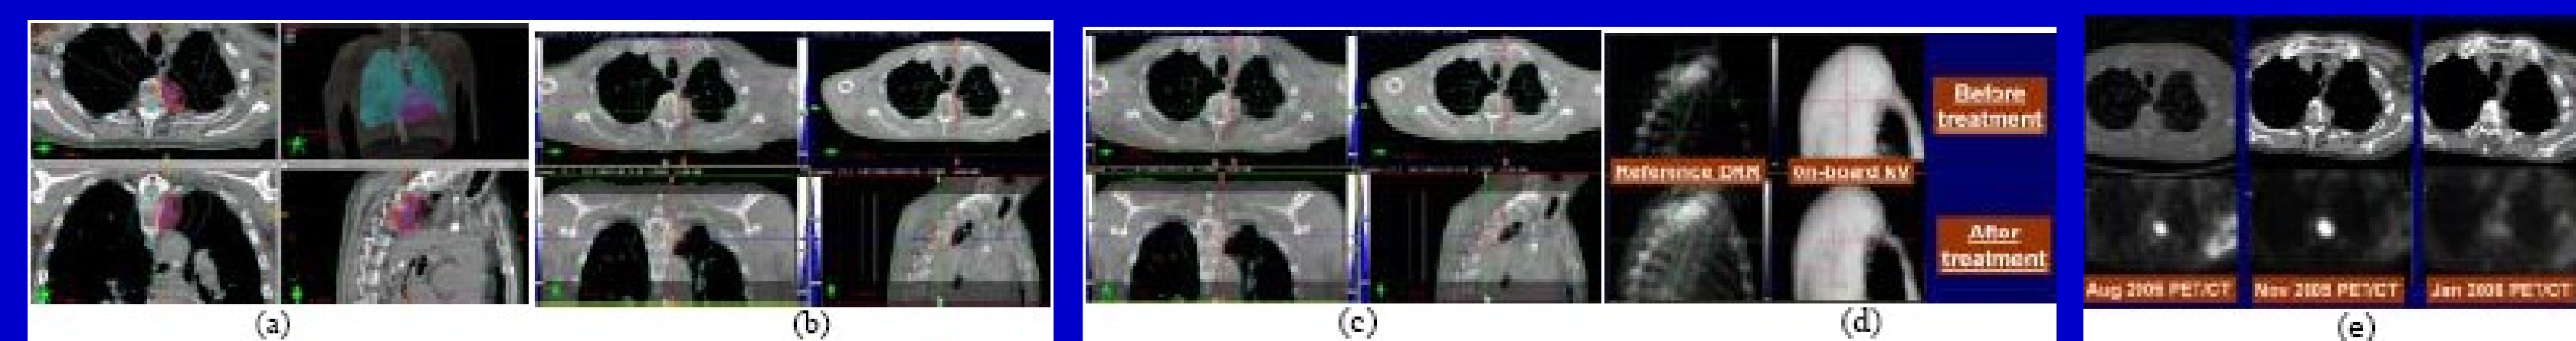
Spine case - 3-D planning (a), 3-D CBCT matching with planning CT [(b)-before matching, and (c)-after matching], 2-D radiograph before and after treatment (d), and treatment outcome of PET images (e).
